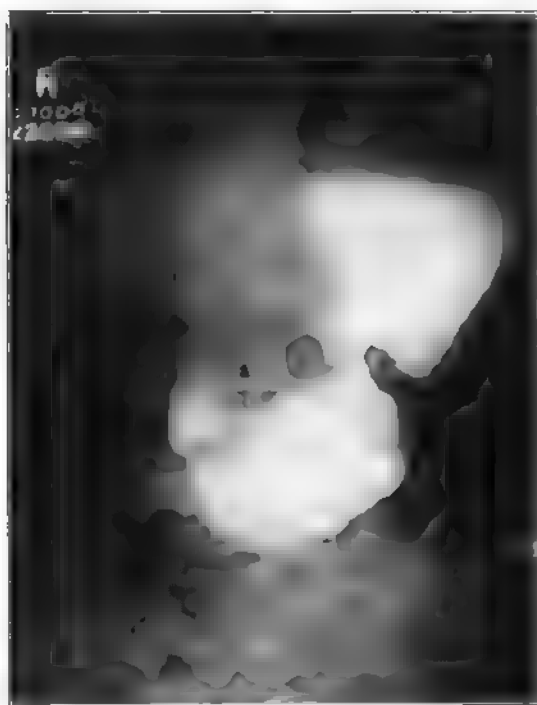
(Case No. A87,718; X-ray No. 93,008.) Male, aged forty-two. Hour-glass stomach with projecting mass on lesser curvature in *pars media*. Small residue in projecting mass and large residue in lower locules after six hours. Operation: Perforating ulcer.
